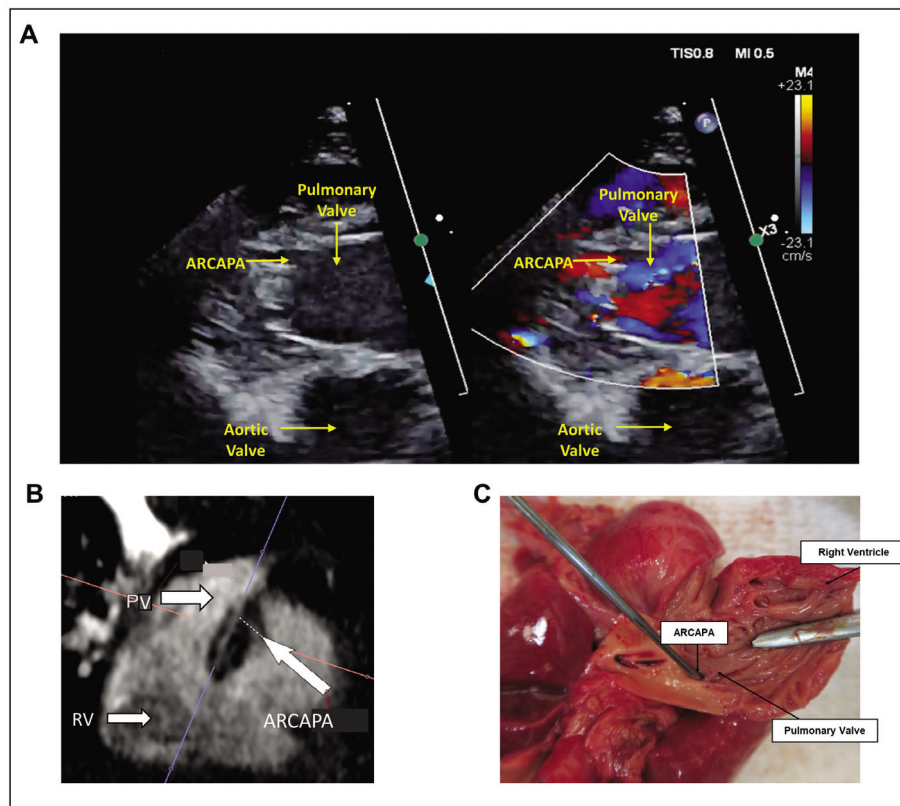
ARCAPA (anomalous right coronary artery from the pulmonary artery) identified on multiple imaging modalities. (A) Short axis echocardiographic images of the pulmonary and aortic valve en face demonstrating ARCAPA arising from the right sinus of the pulmonary valve. (B) Coronal computed tomography image with the RV and PV with the ARCAPA (arrows) and (C) autopsy image with the RV, PV, and a probe in the ARCAPA (arrows). ARCAPA, anomalous right coronary artery from the pulmonary artery; PV, pulmonary valve; RV, right ventricle.
